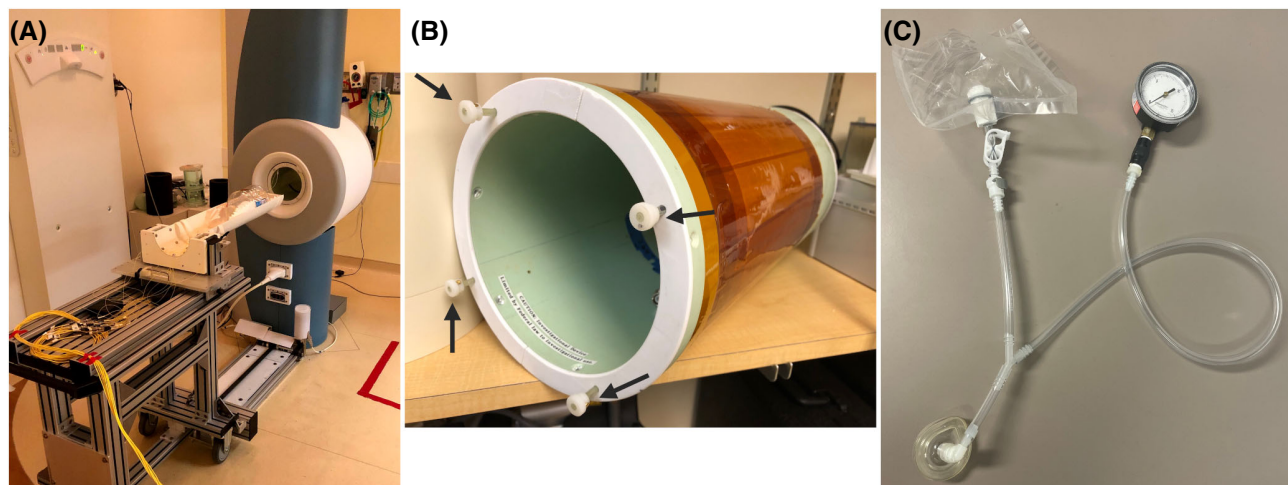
MRI equipment set-up: (A) neonatal MRI scanner and patient table. (B) ^1H - ^{129}Xe RF coil, with frequency switching via insertion/withdrawal of mechanical rods (arrows). (C) Breath-hold gas delivery apparatus with Tedlar bag, pressure gauge, and clinically available neonatal face mask.
